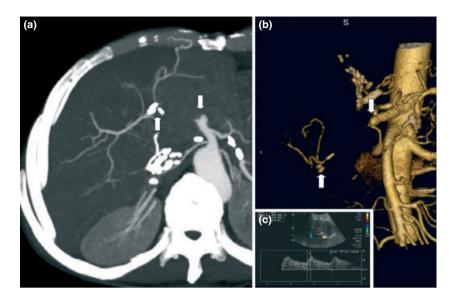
CT-scan and the three-dimensional vascular reconstruction of patient 1. (a and b): arrows indicate the complete common hepatic artery occlusion (↓) and the new parenchyma neovascularization (NV) originating from the right internal mammary artery (↑). (c): Hepatic echo-color-Doppler at 5-year post-hepatic artery (HA) ligature followup: presence of intrahepatic right artery signal with a resistive index (RI) of 0.47.
